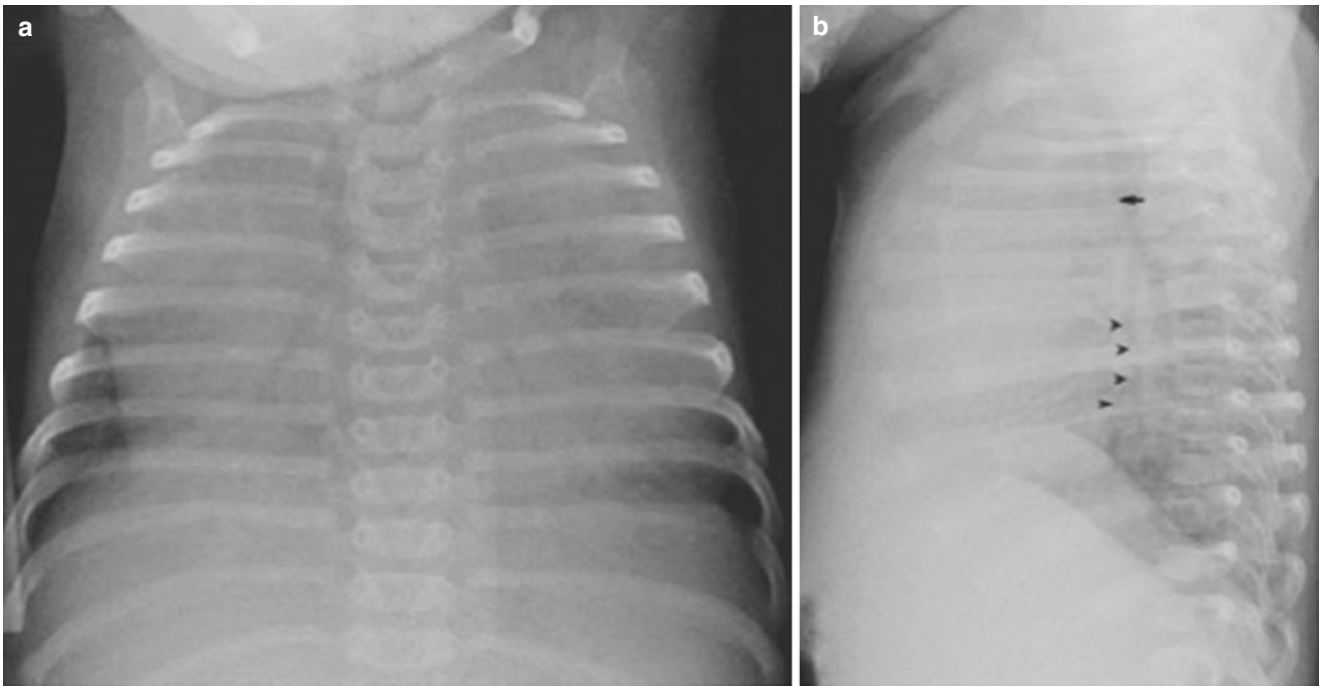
(a, b) AP and lateral radiographs in an infant with a large central soft tissue which nearly opacifies both hemithoraces. The lateral radiograph demonstrates that the posterior margin of the heart (*arrow-*
